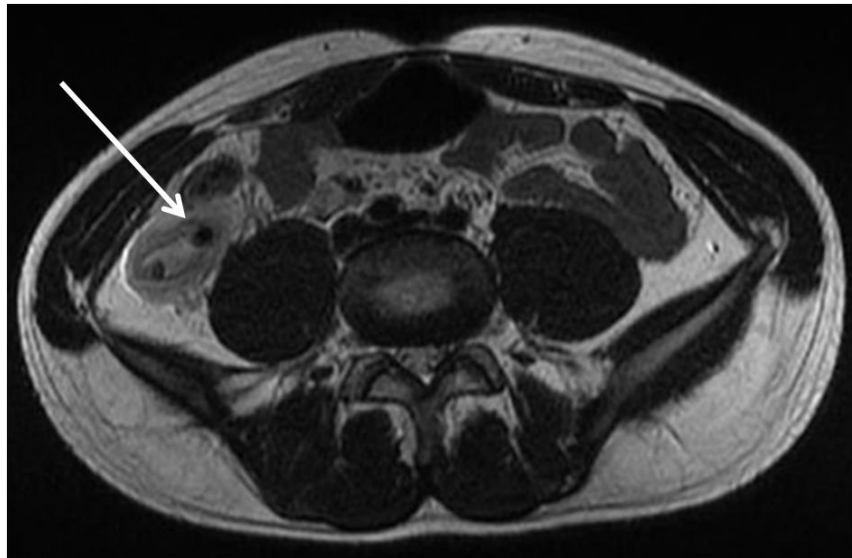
Appendicitis using nuclear magnetic resonance imaging
